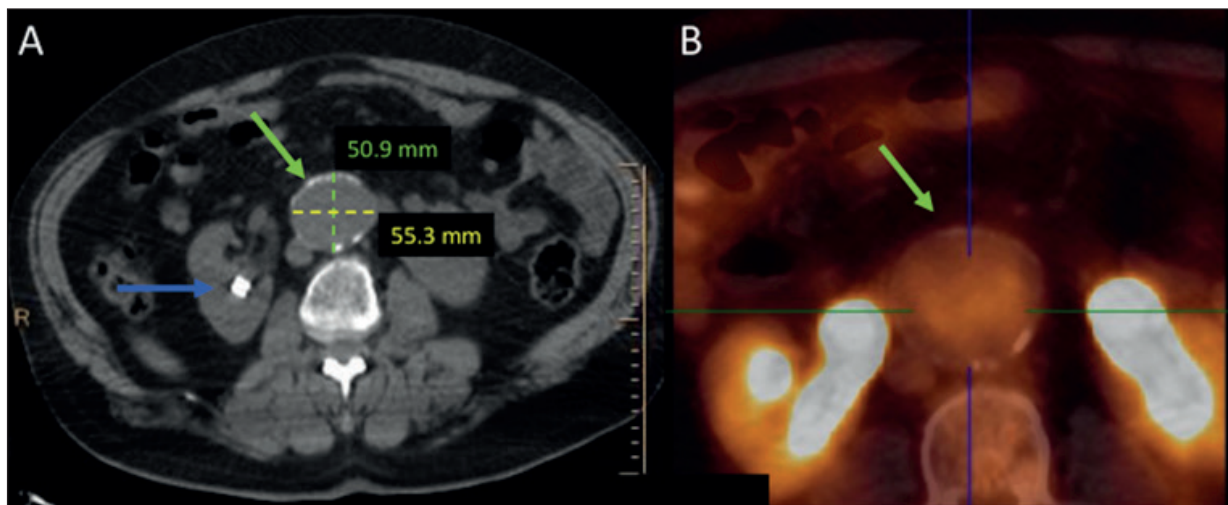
Incidental findings in a 61-year-old multiple myeloma patient who underwent [^{18}F]FDG-PET/CT for post-therapy (chemotherapy and immunosuppressive therapy) restaging. A right kidney stone (blue arrow), classified as nM2-IF, and an aortic aneurysmal dilatation (green arrows), classified as nM4-IF, were detected on (A) co-registered CT. B, Axial fused PET/CT image.
